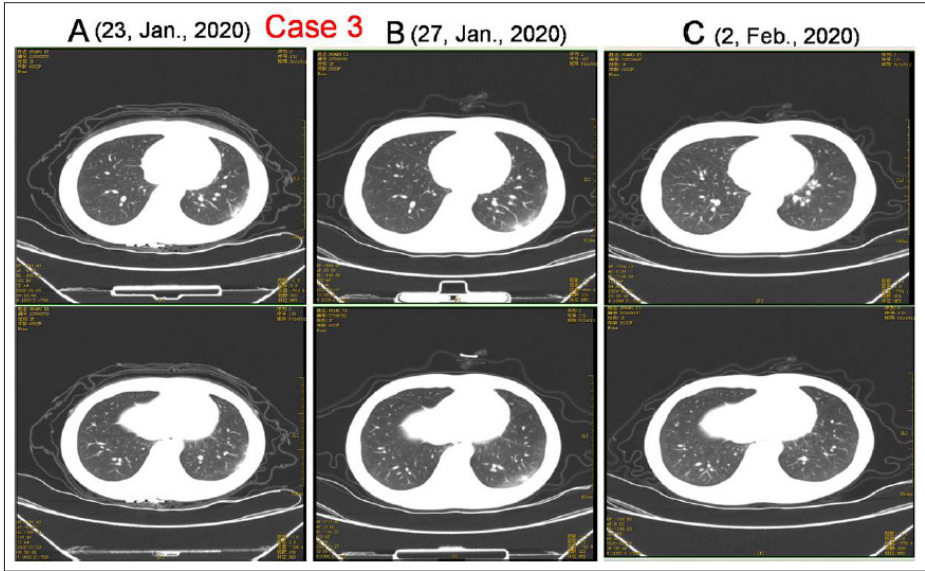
Chest CT Imaging of Patient 3
